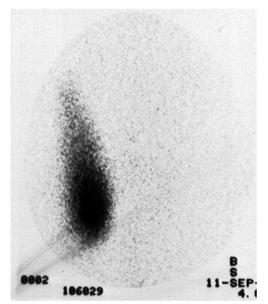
Tc-99m scintigraphy demonstrates the absence of the left thyroid lobe and hot spot uptake at the inferior pole of the right lobe.
